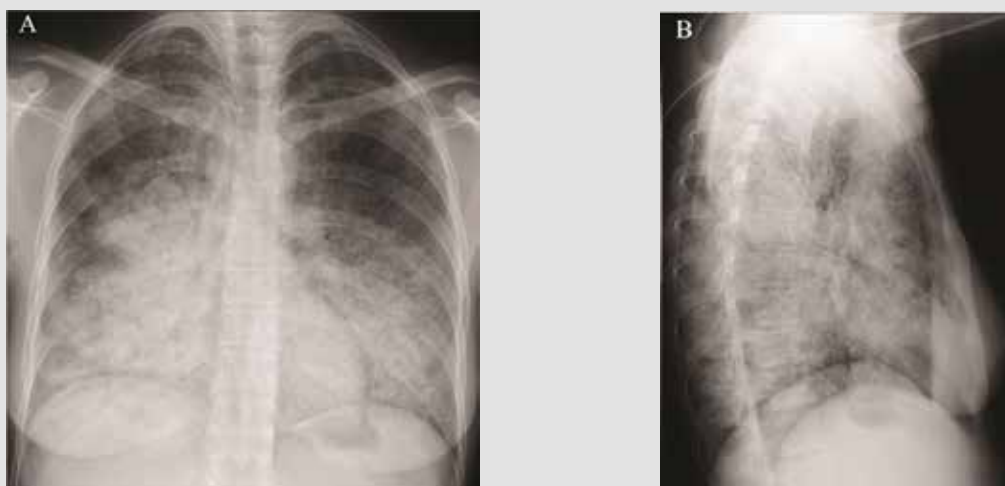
(A) Posteroanterior chest radiograph demonstrates bilateral extensive air-space filling with some sparing of the apices and lateral left base; (B) lateral radiograph of the same patient demonstrates diffuse pulmonary infiltrates that are confluent at both lung bases.
